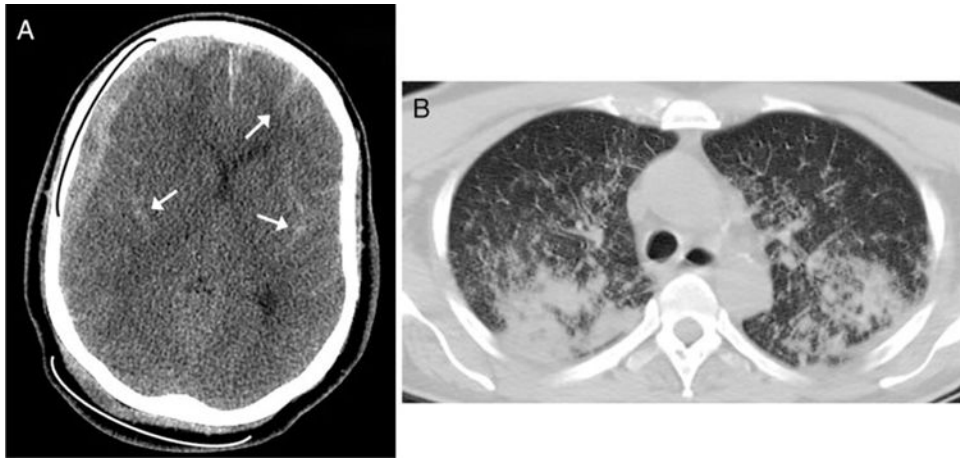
Hemorrhagic manifestations in case 1. *A*, Computed tomography (CT) of the head without contrast enhancement demonstrating right-sided subdural hemorrhage (*black arc*), diffuse subarachnoid hemorrhage (*arrows*), subgaleal hematoma (*white arc*), and a 5-mm right-to-left midline shift. *B*, CT of the chest without contrast enhancement demonstrating diffuse alveolar hemorrhage.
